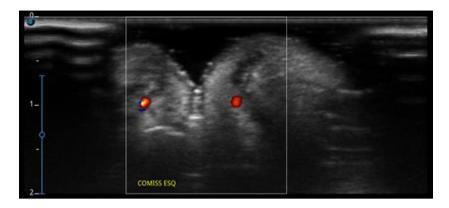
Left Labial Commissure Region, using ultrasound equipment with Doppler functionality, featuring the transducer positioned vertically, highlighting the superior and inferior labial arteries
